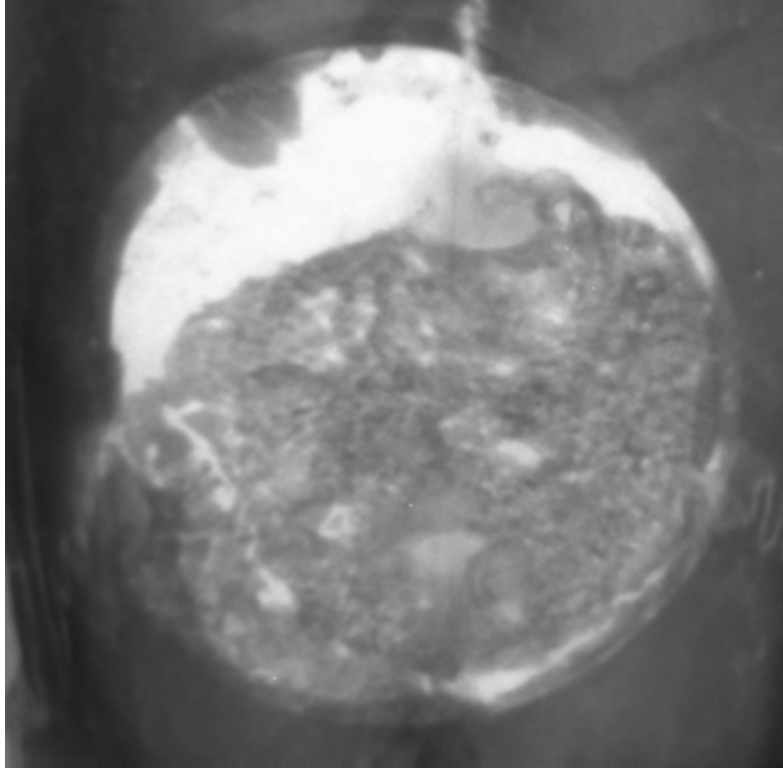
Micro CT image of DuraGen® + MSCs at 4 weeks
